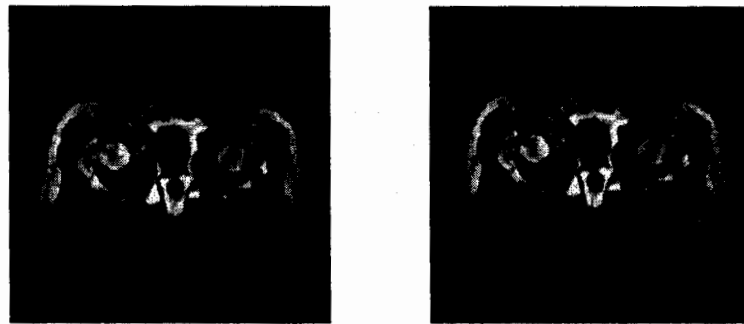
Scaled CT and MR Images of Pelvis by Proposed Method
